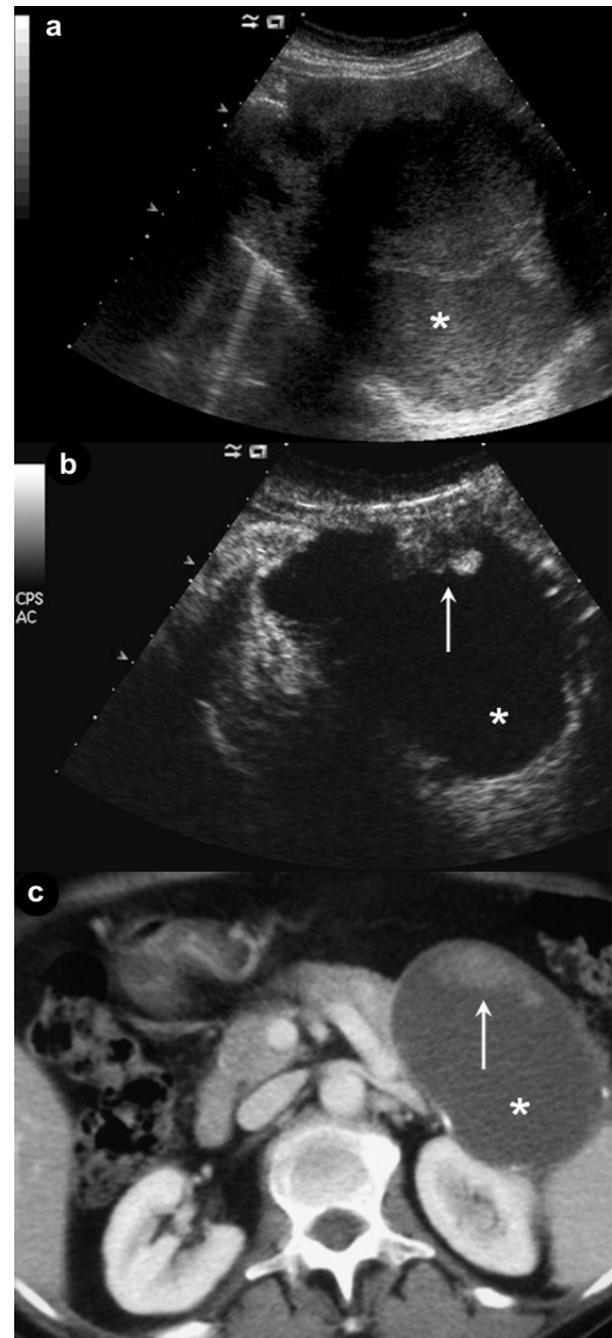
Mucinous cystadenocarcinoma. a. US: cystic pancreatic tail mass with non-homogeneous content (asterisk). b. CEUS: nodular enhancement (arrow) is clearly visible in the anterior portion of the cystic tumor (asterisk). Note that the non-homogeneous content resulting from mucinous content is no longer visible during the dynamic phases; a better situation for septa and nodules detection. c. CT: cystic pancreatic tail mass (asterisk) with a hyperdense nodule on the anterior wall of the lesion.
